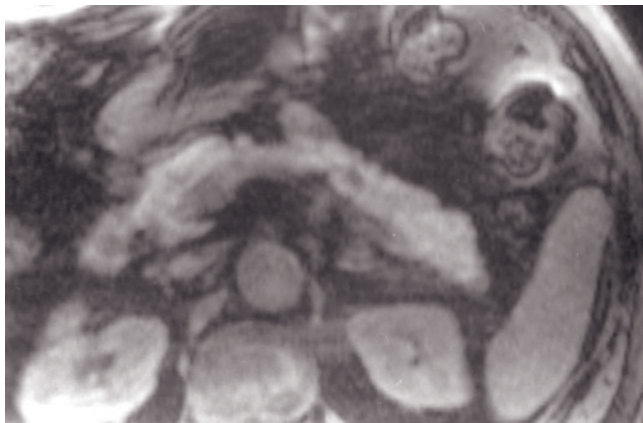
Pancreatic lipoma. T2-weighted SS-ETSE (a), T1-weighted SGE (b), T1-weighted fat-suppressed SGE (c), T1-weighted out-of-phase SGE (d), and 90-s postgadolinium T1-weighted fat-suppressed SGE (e) images. There is a small lesion in the anterior aspect of the head of the pancreas (arrow, a), which appears isointense with adjacent intraperitoneal fat on T1 (b)- and T2 (a)-weighted images, with drop in signal intensity on fat-suppressed images (c, e). A phase-cancellation artifact surrounds the lesion on the T1 out-of-phase image (d). These findings are diagnostic for a pancreatic lipoma.
